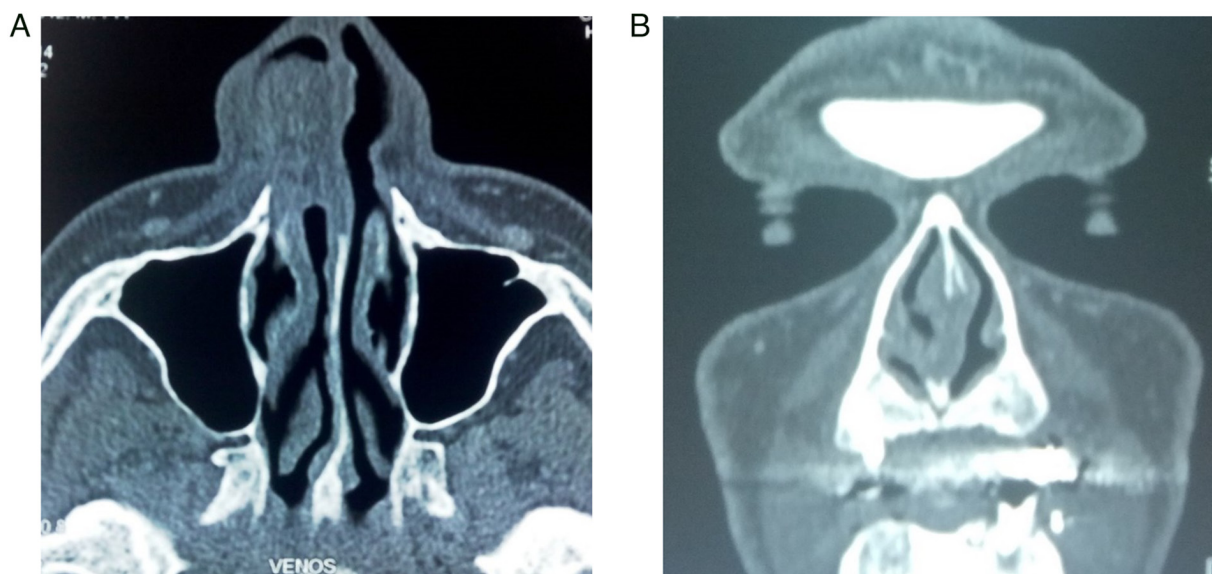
Enhanced CT scan. Well-circumscribed enhancing mass totally obstructed the nasal fossa. (A) axial and (B) coronal section.
